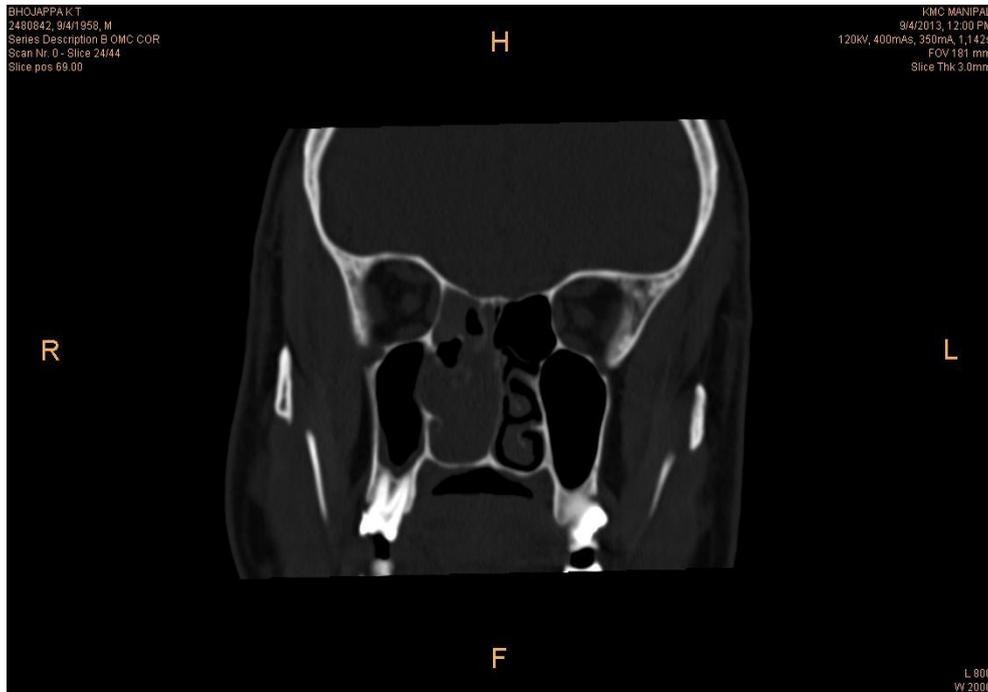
CT scan, Coronal section- Soft tissue density mass filling the right nasal cavity partly extending into the right maxillary sinus through inclined maxillary ostium and infundibulum with deviation of the nasal septum to the left
